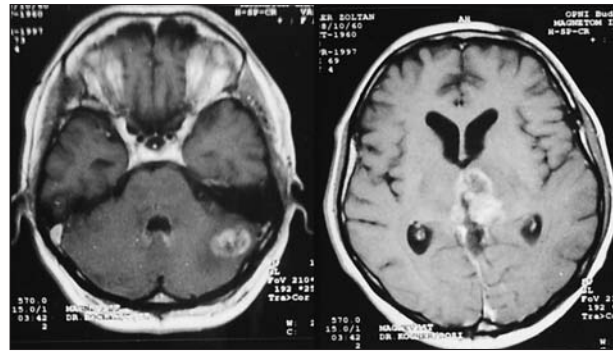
Preoperative axial T1-weighted MRI obtained with contrast material demonstrates a hyperintense mass in the region of corpus pineale, in the posterior part of both thalamus and the region of aqueductus cerebri
